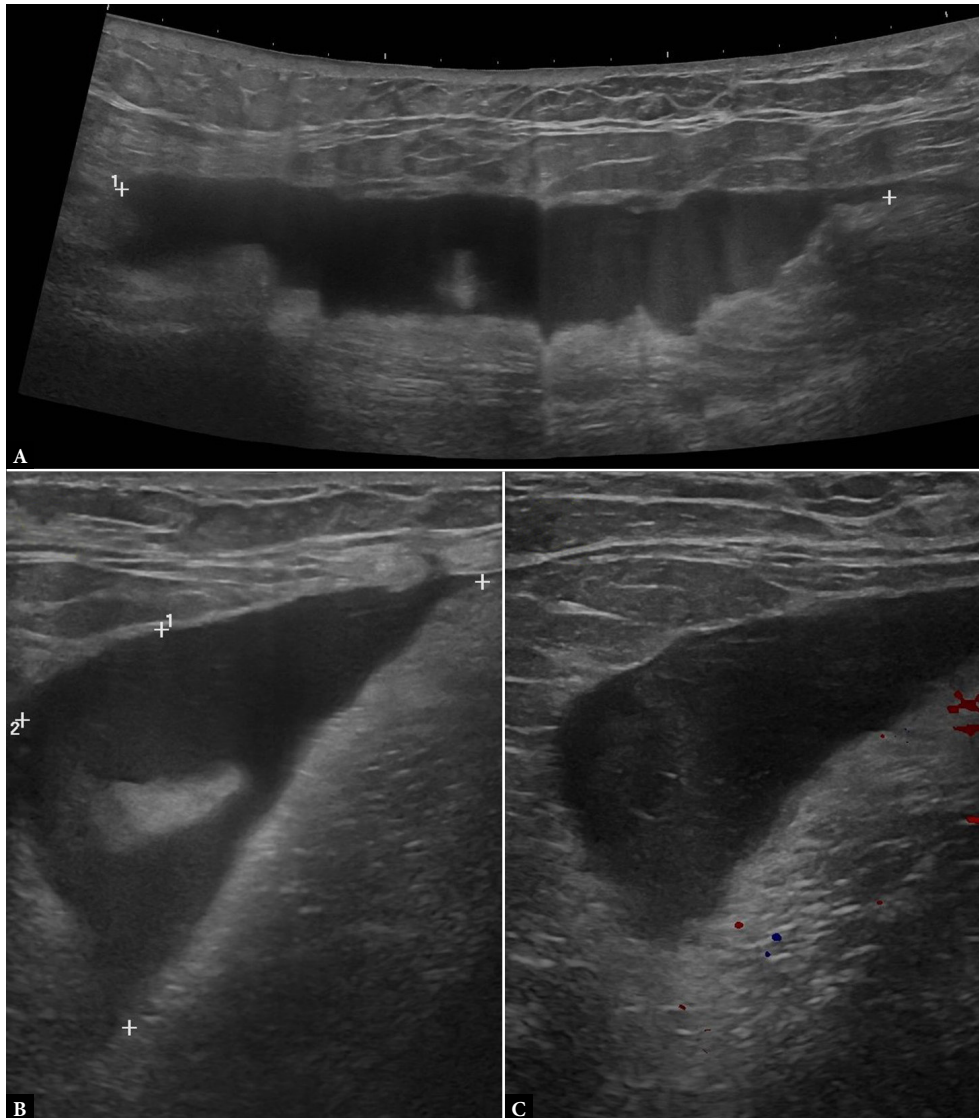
Ultrasound of the right gluteal region demonstrating a large subcutaneous anechoic collection (13.6 × 4.9 × 5.9 cm) with internal particulate content (A, B) and no flow on CD (C), consistent with a subacute hematoma
